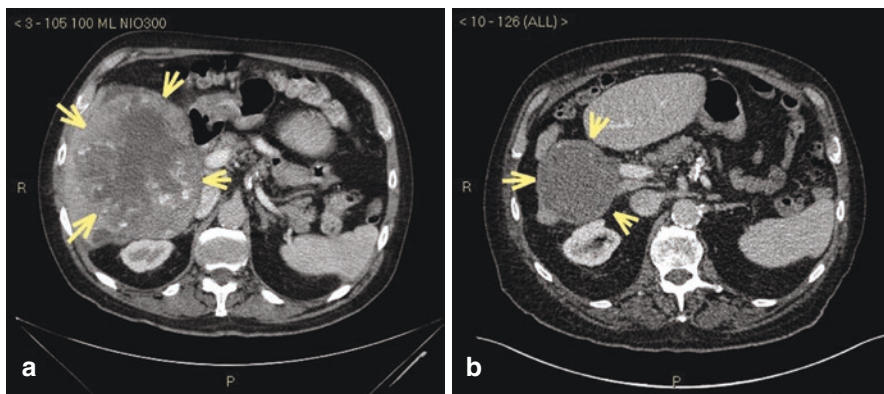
(a) MRI scan shows a large hypervascular right-sided liver lesion. This demonstrated wash-out on the portal-venous phase of dynamic imaging. (b) The same patient scanned 10 years later. There has been a marked reduction in size of the lesion
